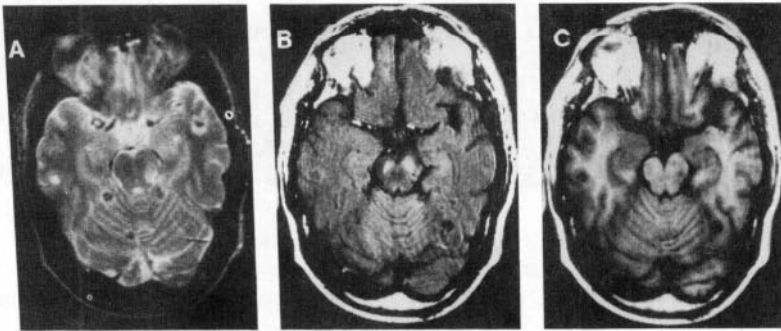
Cysticercosis. T2-weighted axial image (a) at the level of midbrain shows multiple hyperintense areas bilaterally with perifocal edema in some. T1-weighted image (b) shows hypointense nature of these lesions. On MT T1-weighted image (c), peripheral hyperintensity is seen in some of the lesions, Postcontrast T1-weighted image (d) shows ring enhancement of the lesions in the left frontal and right occipital region.
